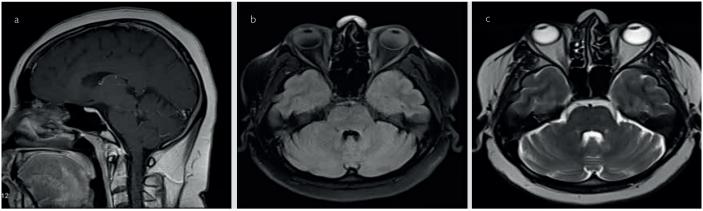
a-c. MRI of the first case at 3 months after corticosteroid therapy showing dramatic reduction in the extent of gadolinium-enhanced lesions. Sagittal FLAIR (a), Axial FLAIR (b), Axial T2 (c) weighted MR images
